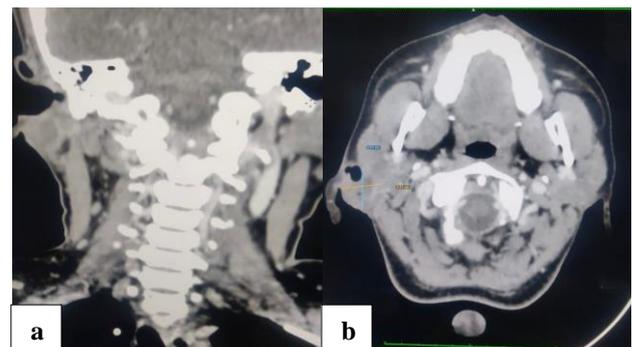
(a) Plain CT neck, and (b) enhanced axial CT scan through the neck.
